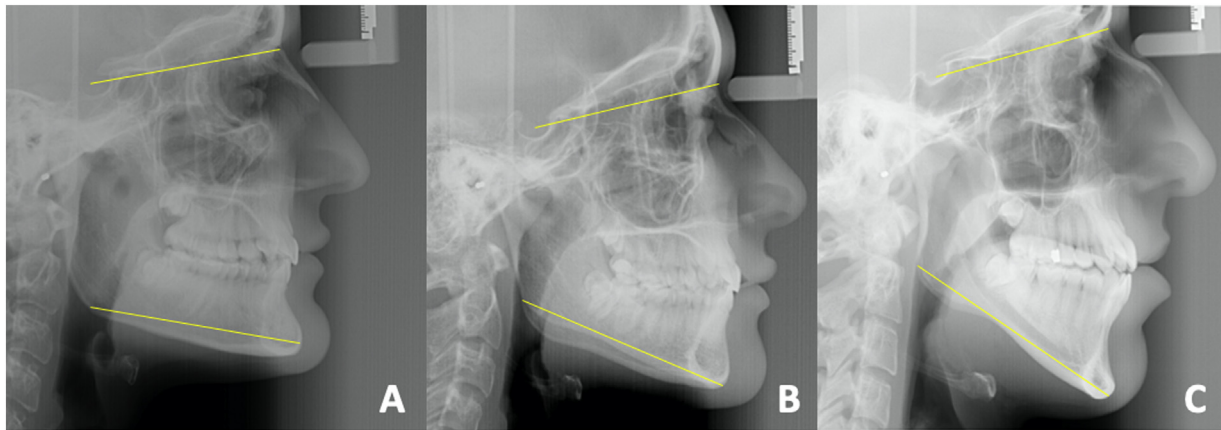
Lateral cephalometric radiographs of different divergence patterns: A. Hypodivergent ($MP/SN \leq 27^\circ$); B. Normodivergent $27^\circ < MP/SN < 37^\circ$; C. Hyperdivergent ($MP/SN \geq 37^\circ$).
